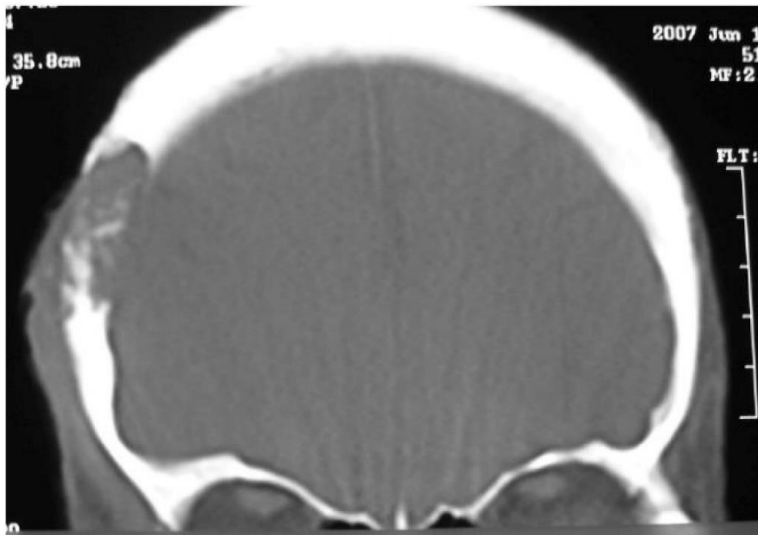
Bony Cronal CT-Scan shows a metastatic lesion of skull by BCC.
